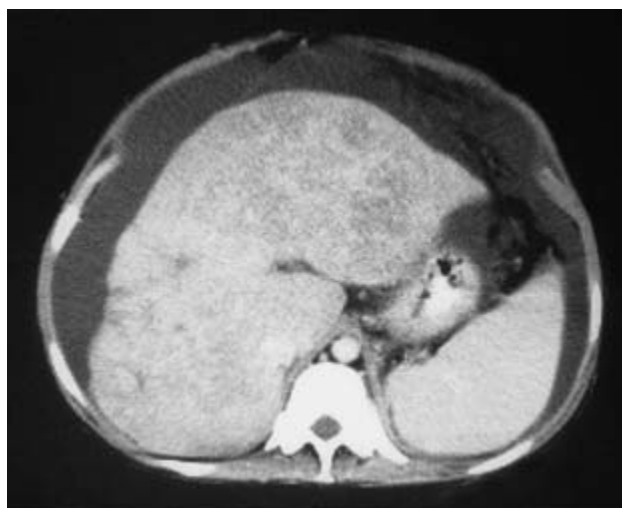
Enhanced CT scan showing patchy areas of low attenuation in the liver (pseudo-tumour appearance) and ascites in a patient with Budd–Chiari syndrome.
